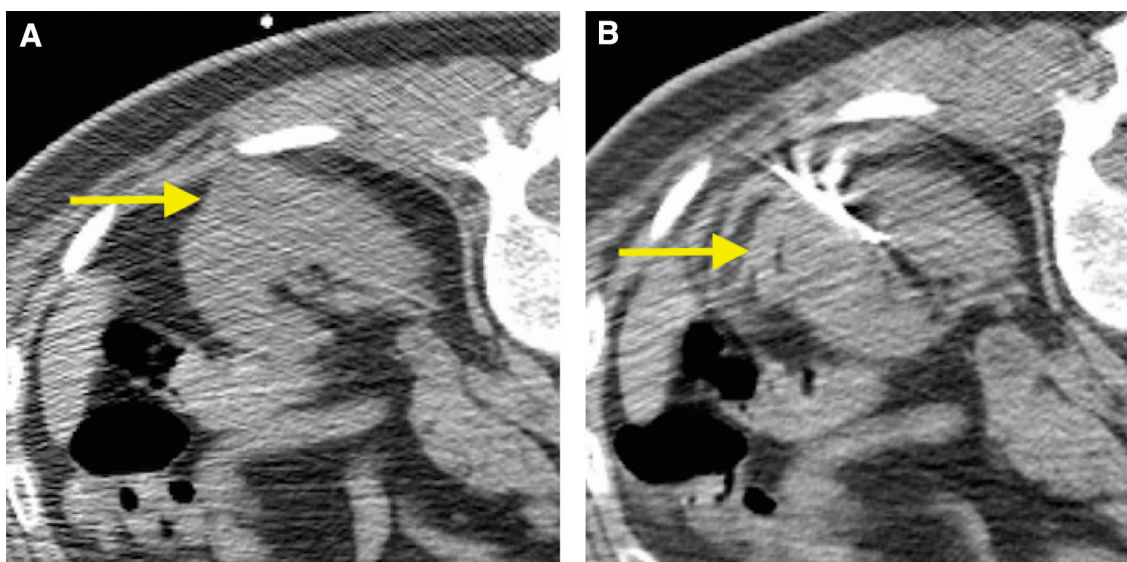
Same session renal mass biopsy and percutaneous thermal ablation for a 65-year-old man with a small renal mass. Axial unenhanced CT of the abdomen (A) with the patient prone demonstrates a partially exophytic small renal mass (≤ 4.0 cm) arising from the posterior, interpolar right kidney (*arrow*). B After the first biopsy pass, the renal mass became
